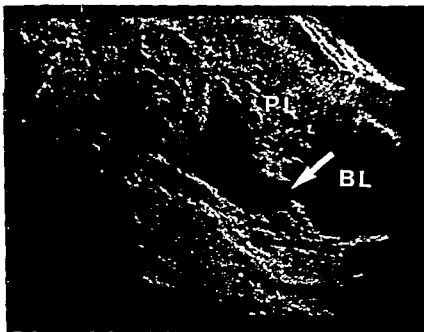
Ultrasonic B scan at the 31st week from the same patient as in Fig 1. Marginal placenta previa.
